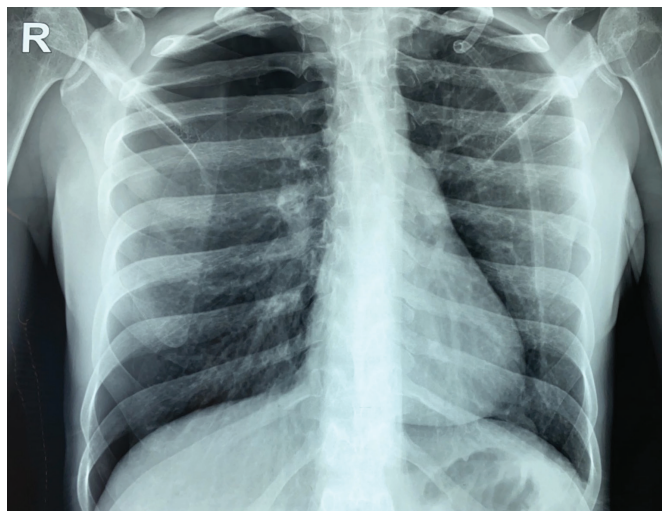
Chest X-ray at hospital admission verifying left-sided pneumothorax
